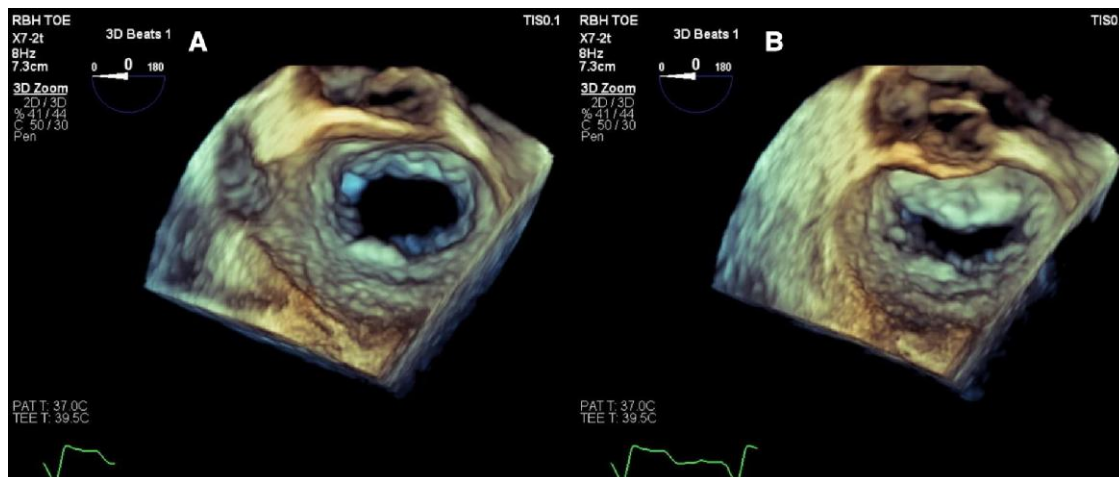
(A) Three-dimensional transoesophageal echocardiography in the mitral valve (MV) ‘surgeon’s view’ highlighting loss of leaflet coaptation with frames frozen at (A) end-diastole and (B) end-systole. The posterior mitral valve leaflet is relatively fixed and immobile. Note the bulky thickening of the whole anterior mitral valve leaflet.
